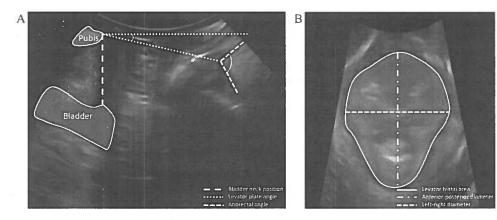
Pelvic floor morphometry parameters as assessed with transperineal ultrasound imaging. A: Mid-sagittal plane. B: Axial plane.
